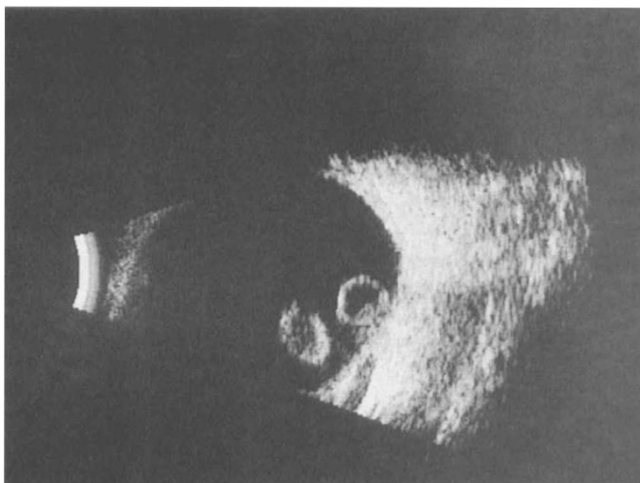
B-mode ultrasound scan of the left eye shows the fixed lens capsule separate from the nucleus which was mobile.
